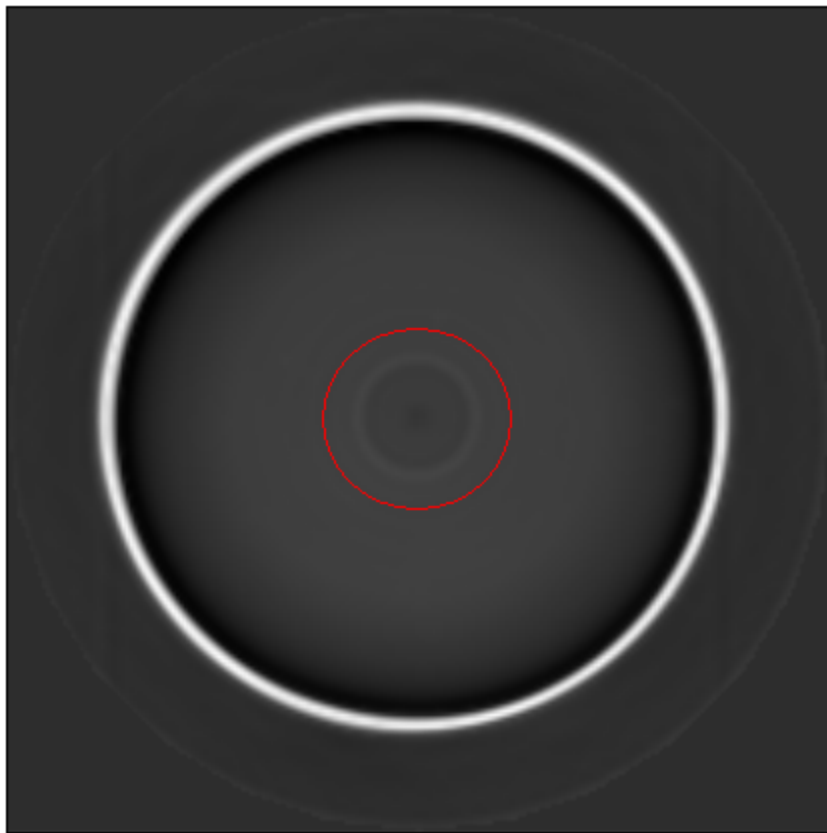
An optical CT ring artifact.
